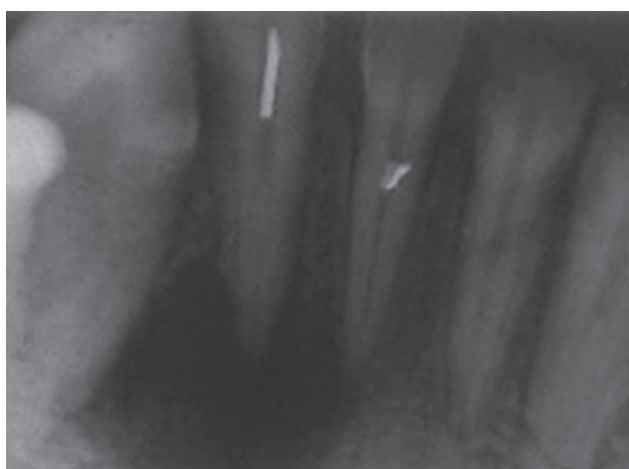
Preoperative radiograph (Case 2)
